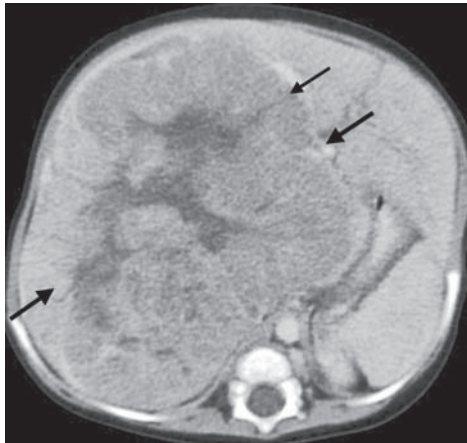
Hepatoblastoma: CT image shows a large well-defined in homogenous lobulated intrahepatic mass (arrows) with slightly lower attenuation and enhancement than the normal liver. Fibrous bands can be seen as unenhanced linear structures
